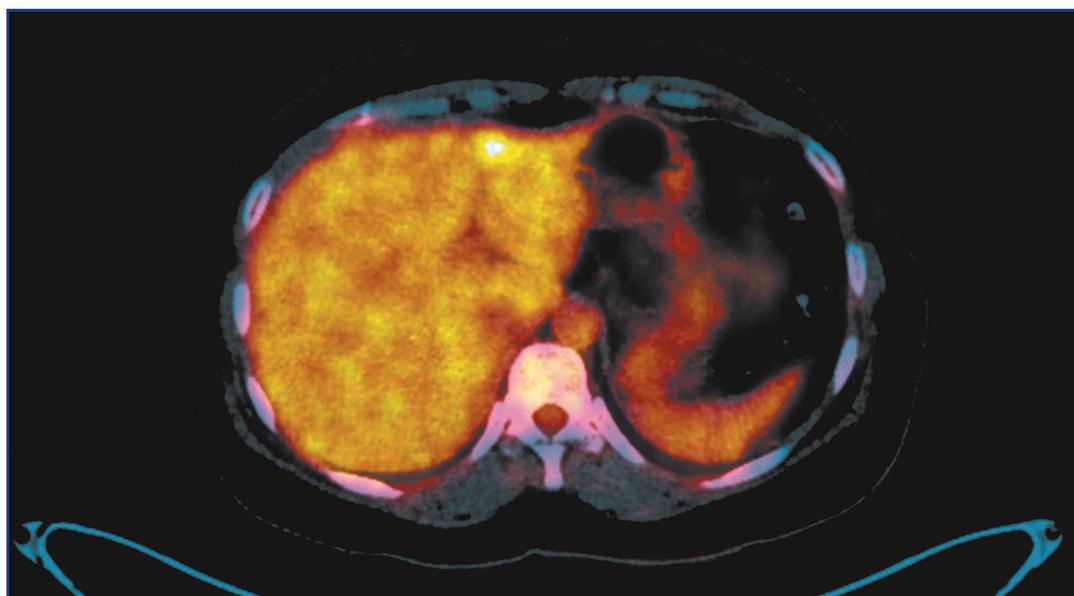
PET/CT. - The metastatic lesion in the parenchyma S1 of the liver segment
